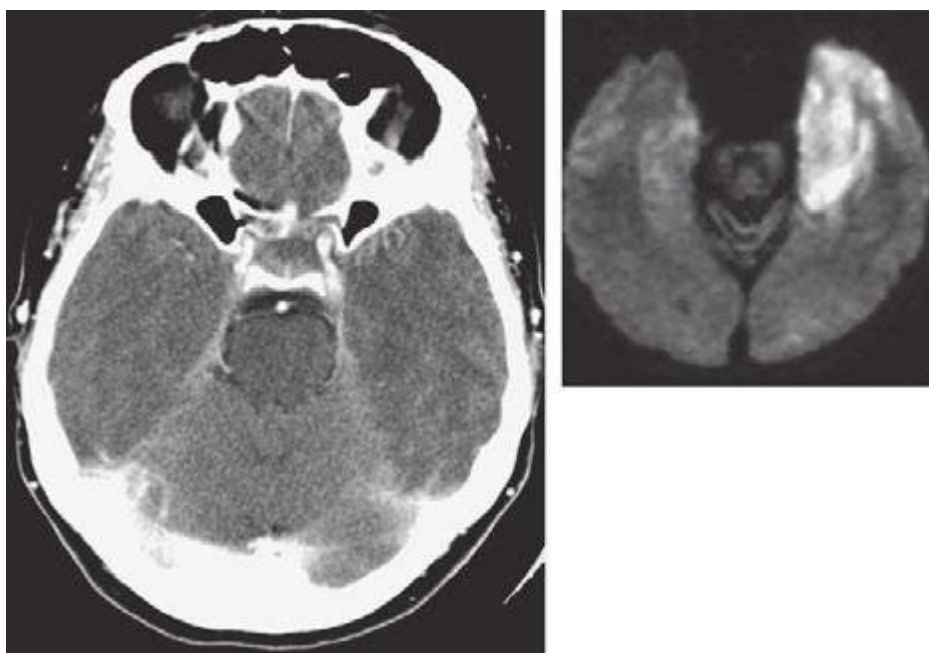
Computed tomography and diffusion-weighted magnetic resonance imaging scans of the brain of a patient with left-temporal-lobe herpes simplex virus encephalitis.
